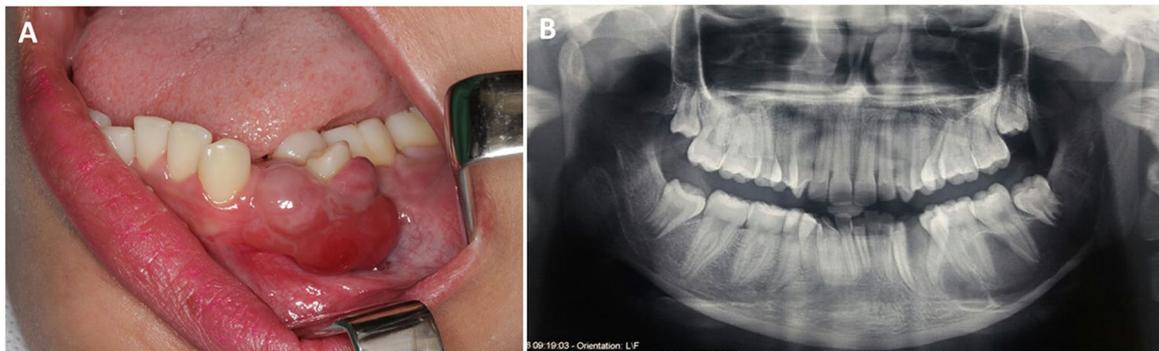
Initial aspect of the patient. A) Clinical image of extra-osseous nodule. B) Initial panoramic radiography.
